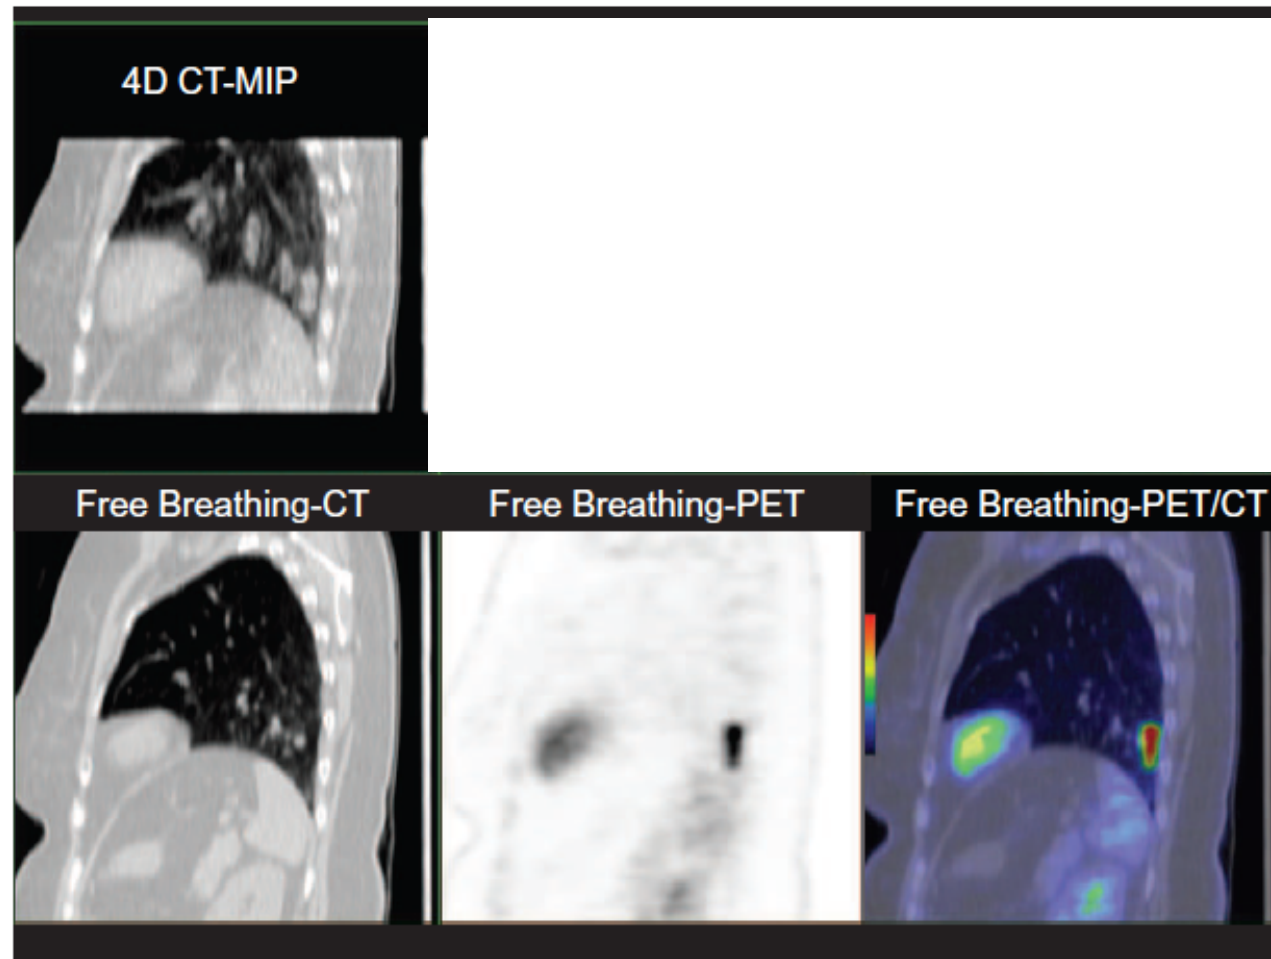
The 4D positron emission tomography (PET)/computed tomography (CT) acquisition (above) and 3D PET/CT acquisition (below) in a patient with a lower lobe tumor, demonstrating CT images (left), PET images (middle), and coregistered PET/CT images (right).
